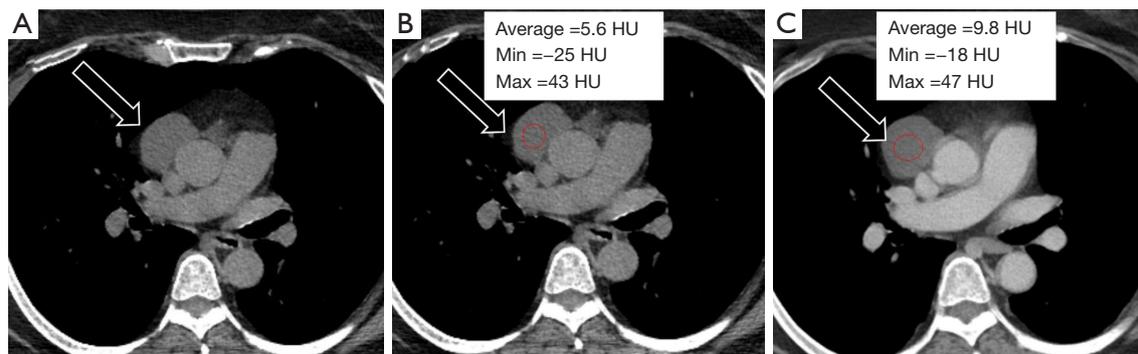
62-year-old female with a thymic cyst. CT imaging demonstrates a low-density lesion in the prevascular mediastinal compartment (A and B, black arrow; circle, average HU =5.6). Contrast administration subtly increases the apparent density of the lesion, but a region of interest confirms persistent fluid-attenuation of the lesion (C, black arrow and circle, average HU =9.8). This lesion was compatible with a thymic cyst on pathology. CT, computed tomography; HU, Hounsfield unit.
